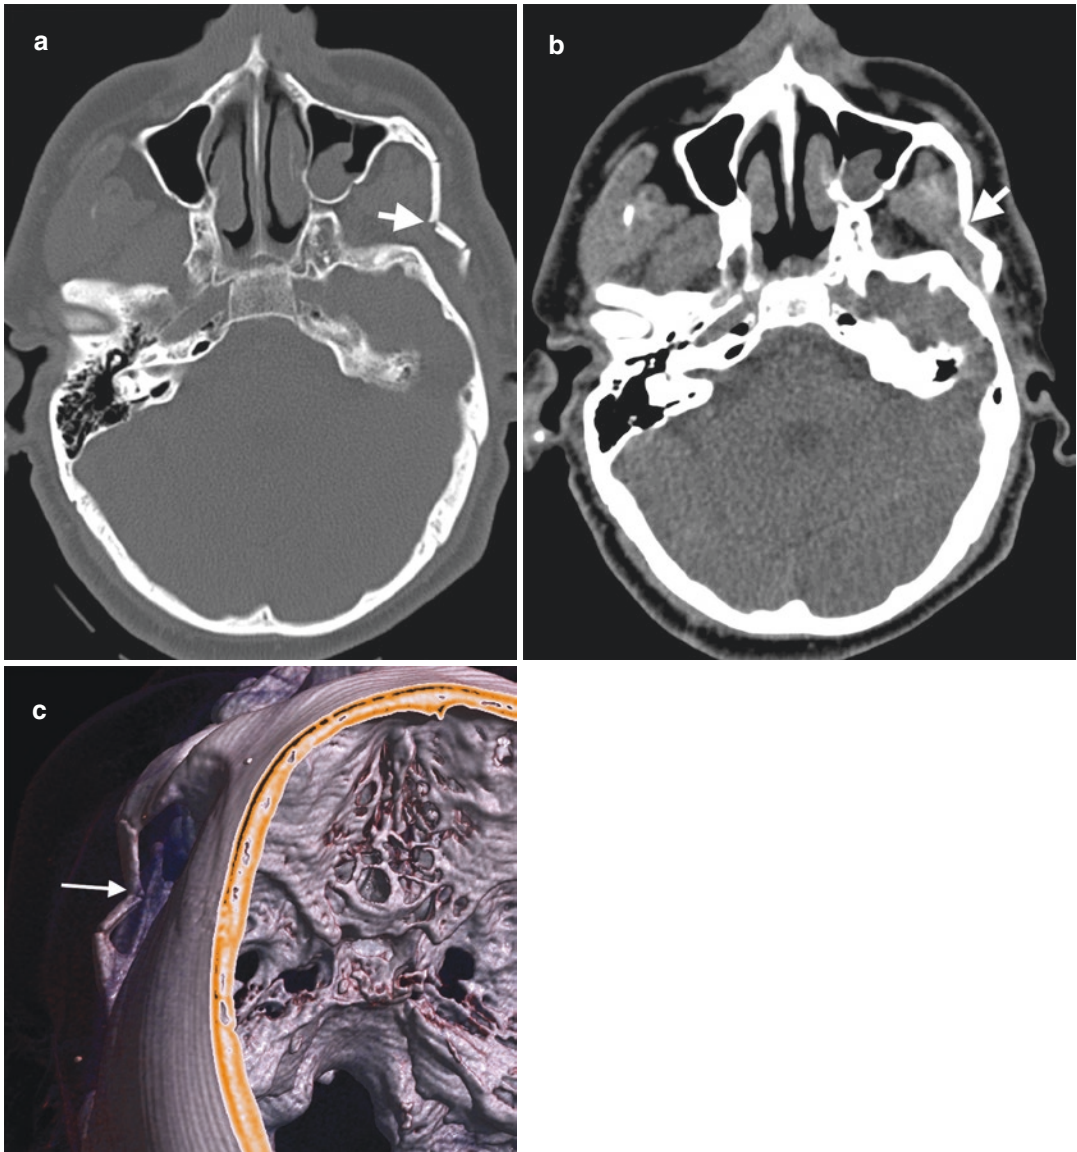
Zygomatic arch fracture in a 51-year-old man presented to emergency service with malar pain and malocclusion after MVA. (a) Axial CT image on bone window shows depressed fracture of left zygomatic bone
